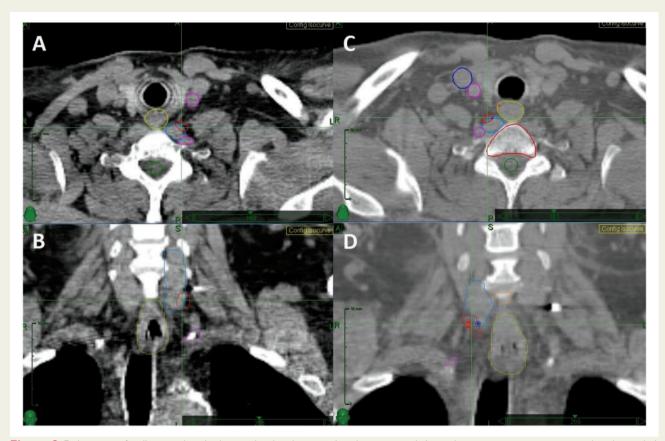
Delineation of stellate ganglion (red, centralized in the images) and organs at risk (oesophagus, arteries, veins, spine, and neck muscles) before ablation therapy using computed tomography imaging. Left-sided structures in transverse (A) and sagittal (B) planes and right-sided structures in transverse (C) and sagittal (D) planes.
